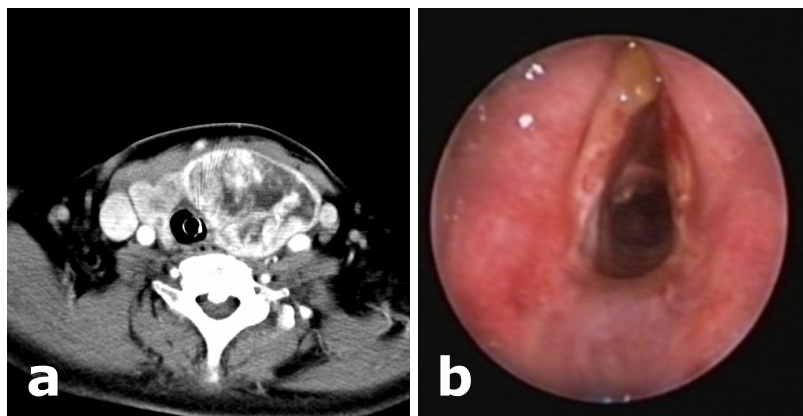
a) Axial computed tomographic image of the neck showing a multinodular goitre with minimal retrosternal extension and no compression on to the tracheal wall (arrow: endotracheal tube seen within the tracheal lumen), b) Endoscopic image of the larynx showing oedematous vocal cords with minimal slough at the subglottis due to intubation.
